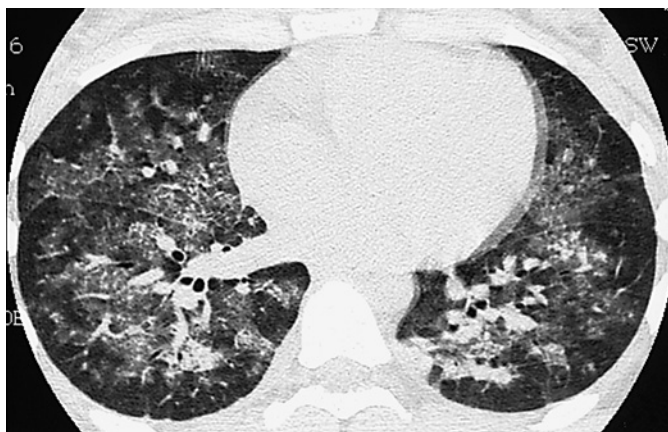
Chest CT demonstrating diffuse ground glass attenuation due to diffuse alveolar hemorrhage in a patient with anti-glomerular membrane disease.
